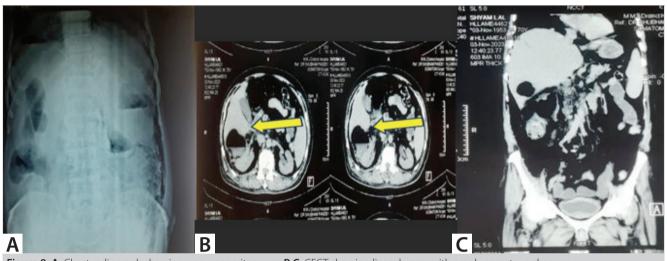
A. Chest radiograph showing pneumoperitoneum. B,C. CECT showing liver abscess with emphysematous changes.
